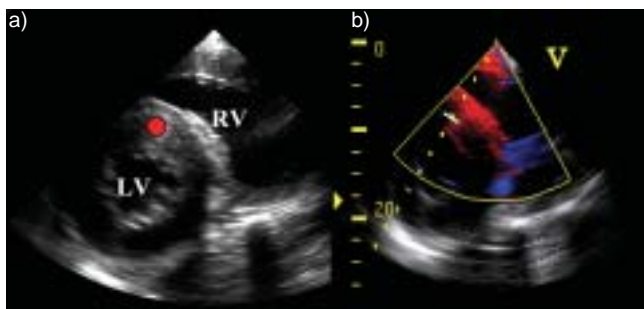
Two-dimensional and colour short-axis right parasternal images at the chordal level showing sampling sites for spectral (red dots) and colour (yellow bar) Doppler tissue imaging in a) the right ventricle (RV) and b) interventricular septum. LV = left ventricle.
